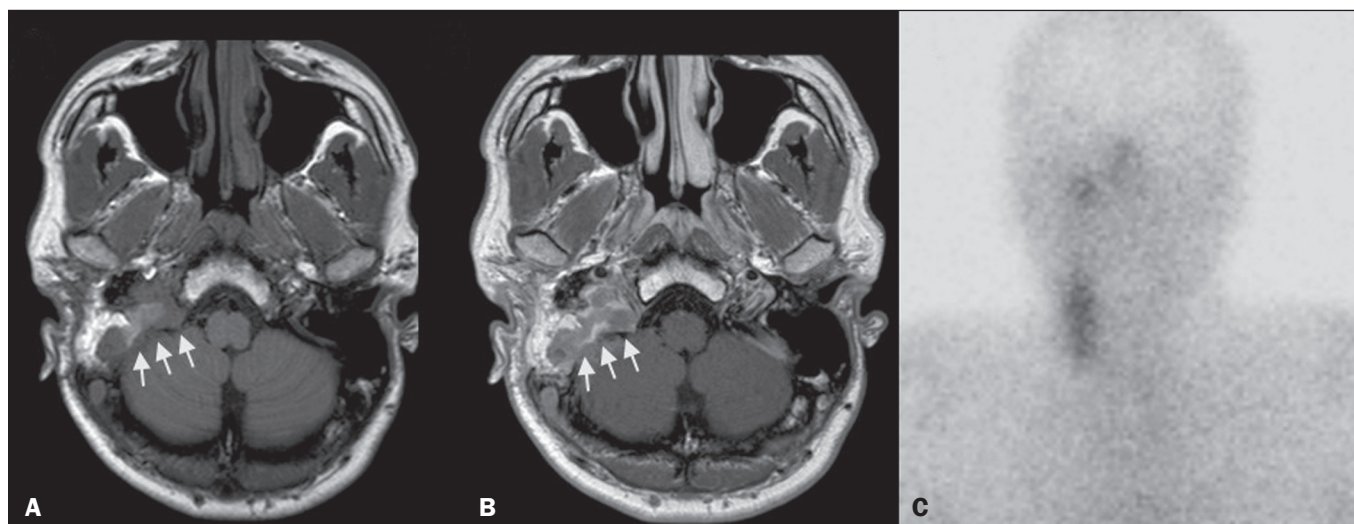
MRI and SRS images of patient A9, in whom the SRS result was positive and the final diagnosis was endovascular meningotheial meningioma. Axial unenhanced (A) and gadolinium-enhanced (B) T1W images showing a heterogeneous soft-tissue lesion (arrows) involving the right jugular foramen and the right sigmoid sinus. The lesion showed intense enhancement after gadolinium administration (B). The hypothesis of paraganglioma was supported by a positive SRS result (C).
